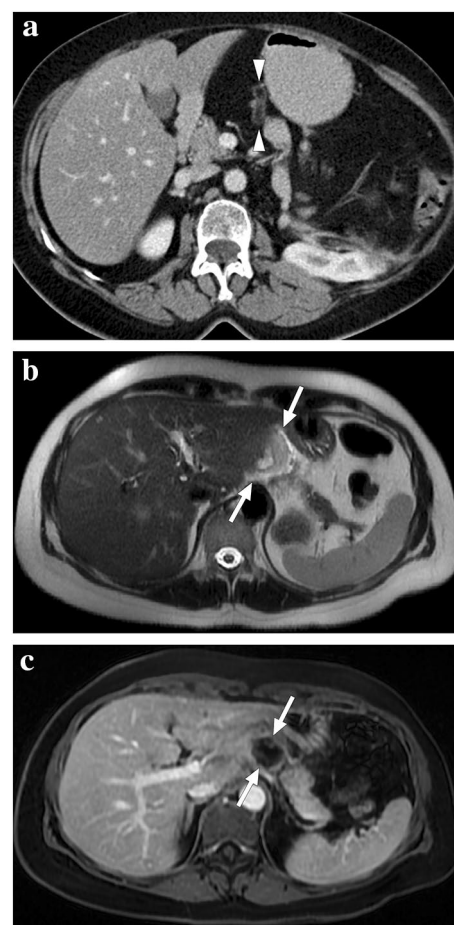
Perigastric appendagitis in two different patients. a 62-year-old female presented with acute onset epigastric pain. Axial plane postcontrast abdominal CT showed an almost entirely fatty, tubular-shaped lesion with a hyperdense rim (arrowheads) in the gastrohepatic ligament. Findings were considered to represent perigastric appendagitis. Her pain completely subsided with supportive medical treatment. b and c A 54-year-old female presented with acute epigastric pain and a hyperechoic mass-like lesion adjacent to the left liver lobe on US (not shown). b Axial plane T2-weighted MR image revealed a mildly hyperintense mass-like lesion (arrows) in the gastrohepatic ligament with surrounding minimal free fluid. c Axial plane postcontrast MR image showed thin peripheral enhancement of this lesion with no apparent enhancement (arrows). Imaging findings were compatible with fat necrosis due to perigastric appendagitis. The patient was treated conservatively and fully recovered
